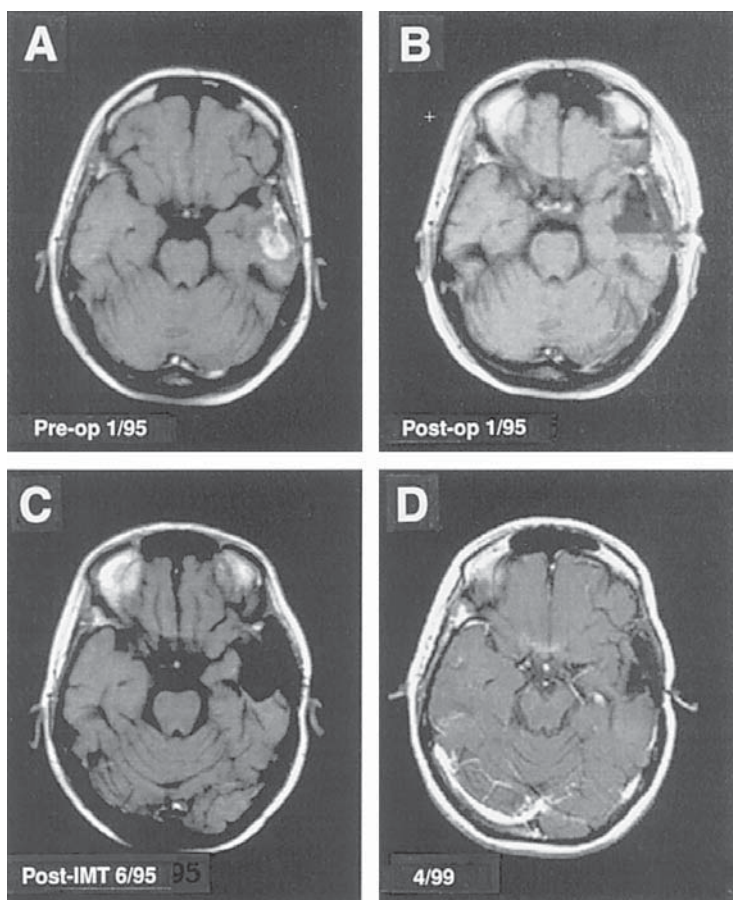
Gadolinium-enhanced MRIs of patient BTP4 were obtained from January 1995 through April 1999. (A) The January 1995 preoperative MRI showed enhancement of tumor medial and posterior to the original operative bed at study entry. (B) The January 1995 postoperative MRI showed minimal enhancement at the margin of the resection site. Blood layered in the posterior aspect of the operative defect. (C) The June 1995 post-IT scan demonstrated minimal enhancement at the margin of the operative bed. (D) Follow-up scan, in April 1999, showed no enhancement around the operative bed and the increased enhancement of the choroid plexus in the left temporal horn, which developed during treatment.
